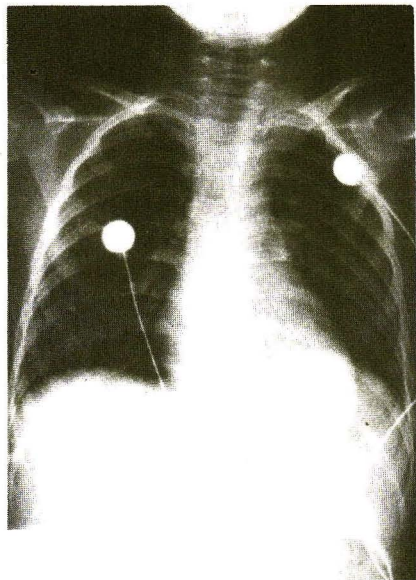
Chest roentgenography showed elevation of the left side of the diaphragm.
